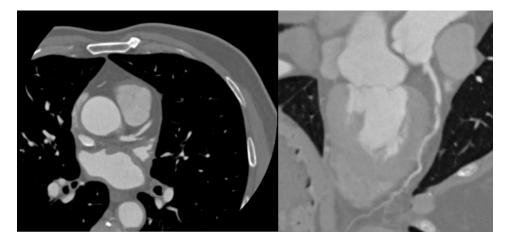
Coronary CT-scan Axial view (left) and Curved MPR view for Artery visualization.
